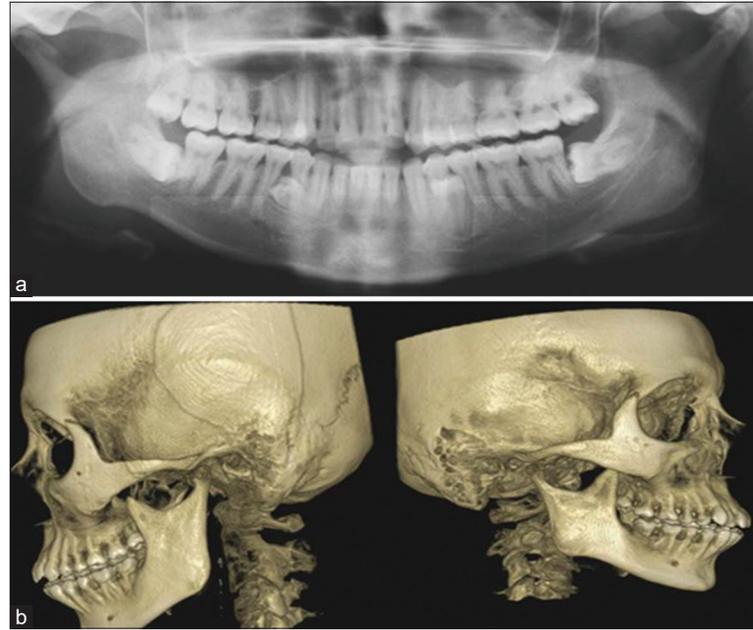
Radiographs (a) orthopantomogram and (b) cone-beam computed tomography.
